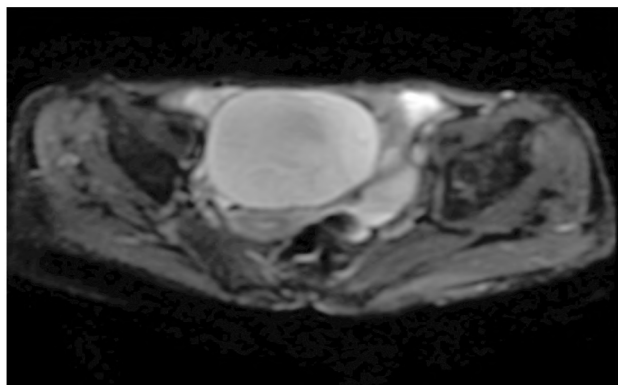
DWI; demonstrate free diffusion.
